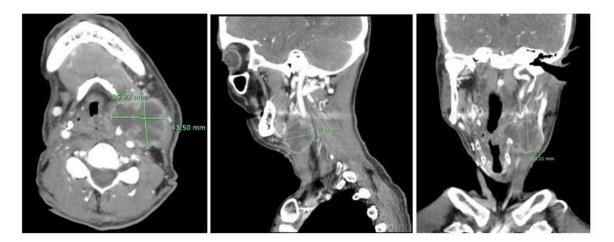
CT Soft tissue Neck with contrast showing large necrotic left neck mass (green indicator) with significant displacement and mass effect on adjacent airway.
